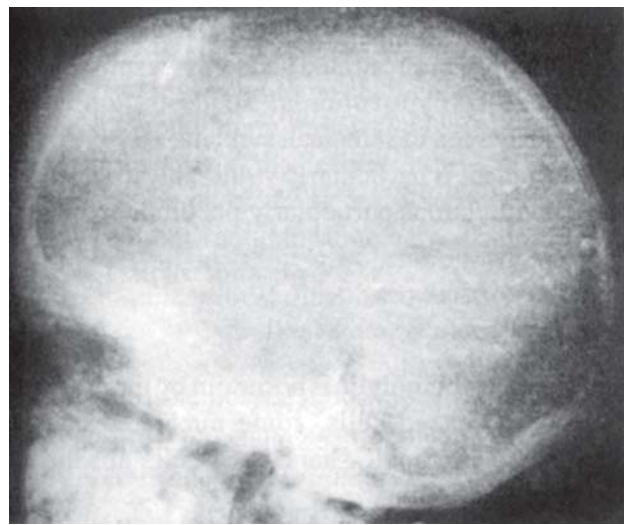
X-ray skull showing "hair-on-end" sign in thalassemia major
